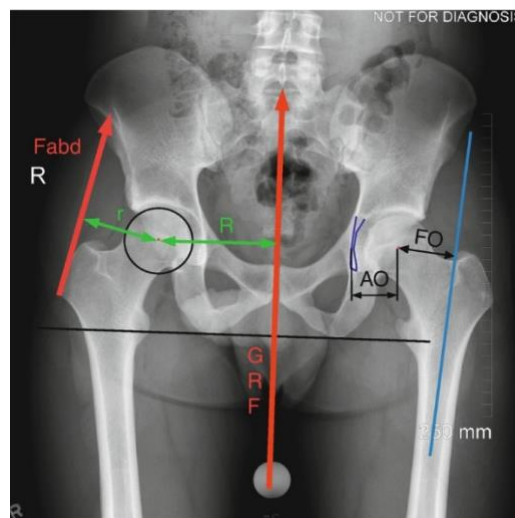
AP pelvis X-rays. F_{abd} : Abductor muscle force; GRF: Ground Reaction Force; FO: Femoral Offset; AO: Acetabular Offset; r : Abductor lever arm; R : Body weight lever arm. Reprinted with permission from [4], CC BY 4.0 <<https://creativecommons.org/licenses/by/4.0/>>.
